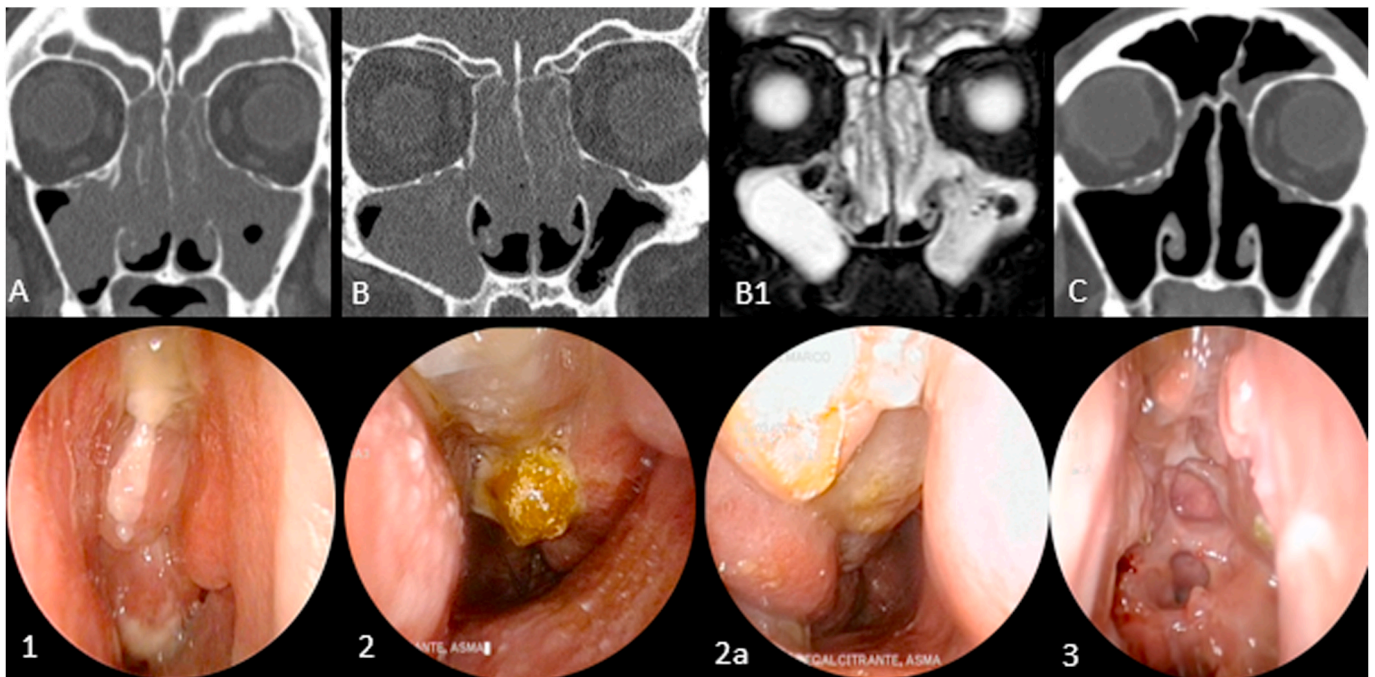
Endoscopic and radiological images in relation to benralizumab therapy and Full FESS. Panels A and 1 (1 week before start of benralizumab): the CT image shows a picture of pansinusitis. Endoscopy of the left nasal fossa shows mucous secretions and a polypoid formation which completely occupies the nasal fossa. Panels B, B1, 2, 2a (6 months after initiation of benralizumab): the endoscopic images of the left (2) and right (2a) nasal fossa, CT scan (B) and MRI (B1) show a largely stable picture compared to the earlier one a week before the start of benralizumab (A and 1). Panels C and 3 (CT at 6 months and endoscopic follow-up 1 year after Full FESS): a clear improvement of the radiologic and endoscopic picture is seen. FESS: functional endoscopic sinus surgery, CT: computed tomography, MRI: magnetic resonance imaging.
